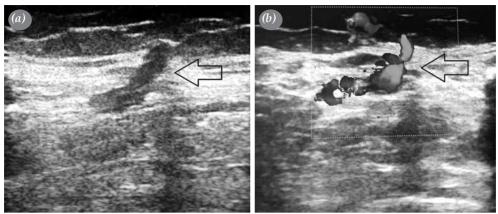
(a) Ultrasound image showing dilated Cockett-2 perforating vein. (b) Color Doppler ultrasound image showing Cockett-2 perforating vein with massive insufficiency.
